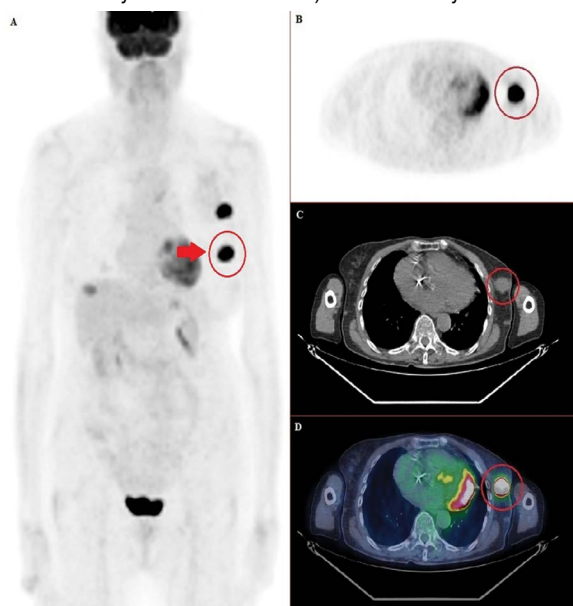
MIP (A), axial PET (B), axial CT (C) and fused PET-CT in FRENCH color (D) images of the same PET-CT scan (left lesion labeled by red circle and arrow)
